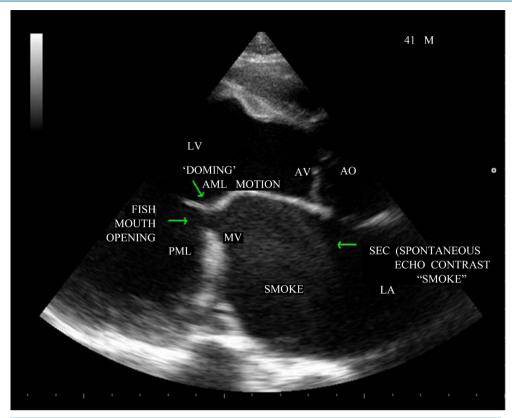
Parasternal long axis view showing the "smoke" in left atrial body.
